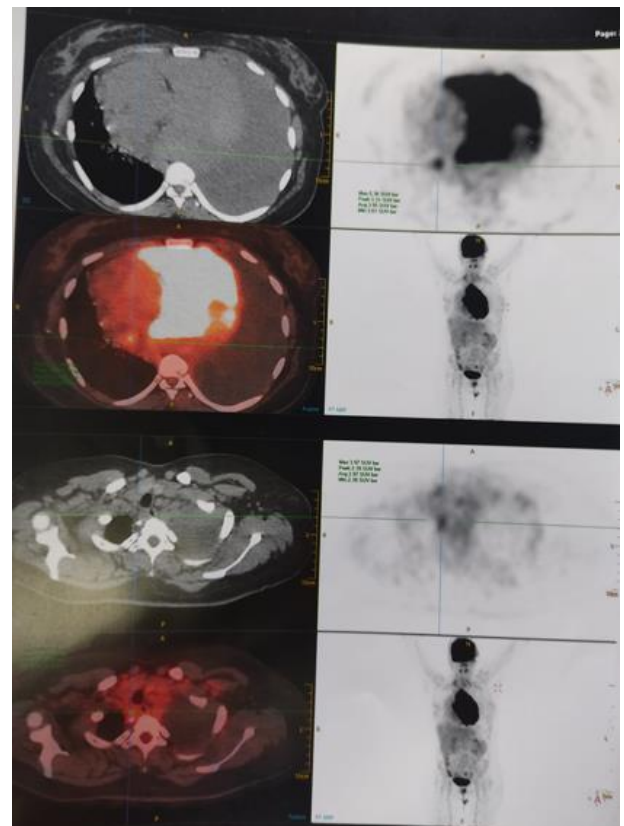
PET/CT imaging showing a large solitary anterior mediastinal mass with intense FDG uptake, without any other suspicious distant foci
